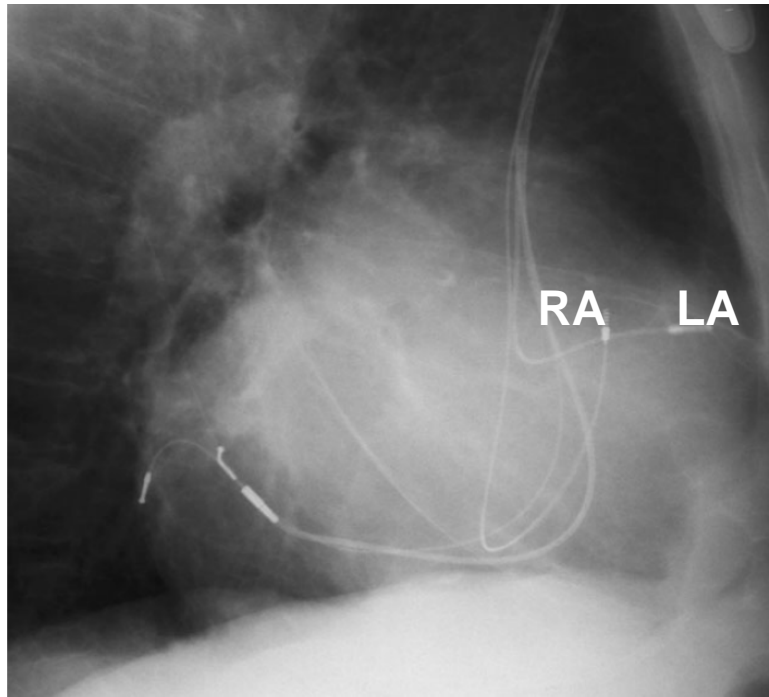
Lateral X-ray view of the first fully transvenous cardiac resynchronization therapy system (courtesy of D.G. and J.-C.D., University Hospital of Rennes, August 1994).
